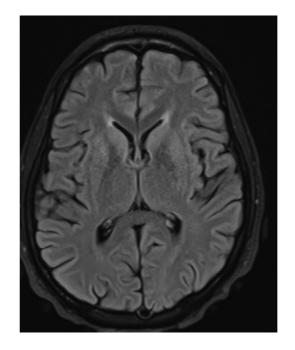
Follow up Axial Brain MRI 2 weeks after treatment with resolution of T2 FLAIR hyperintensity in bilateral basal ganglia.
